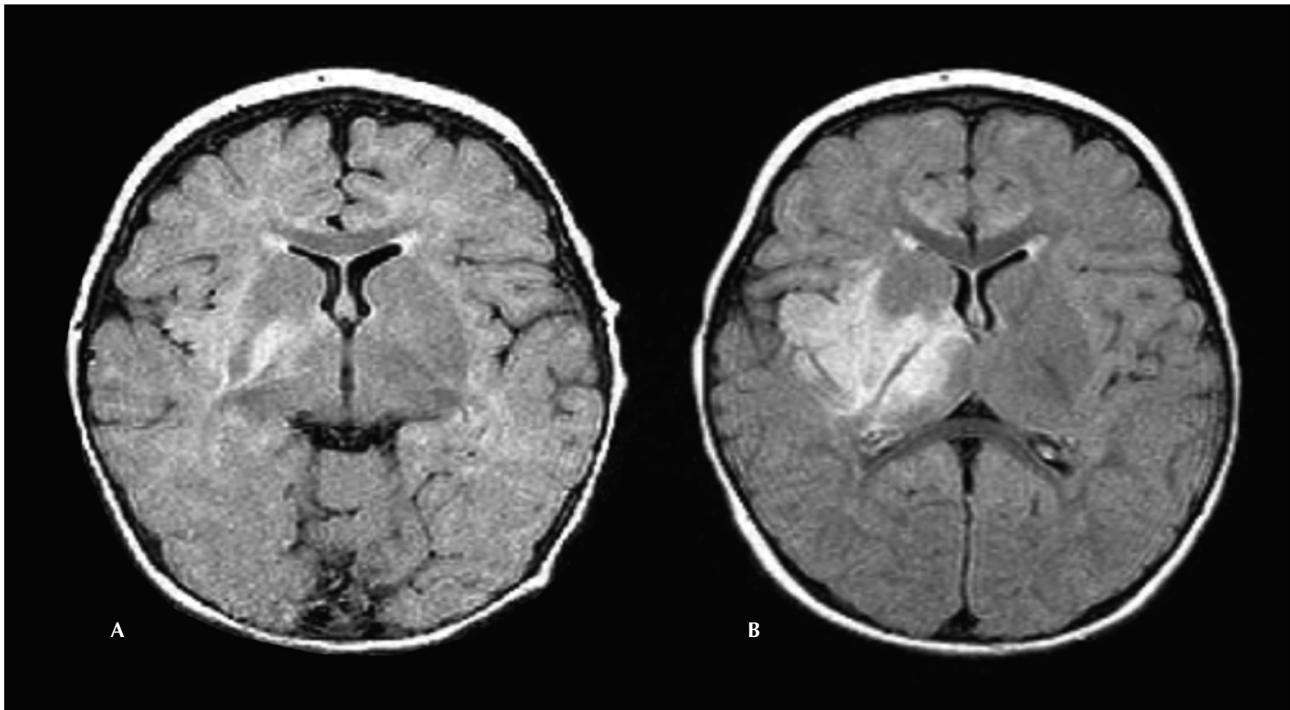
A) MRI brain; FLAIR images (TR 9002, TE 129.7, inversion time 2200) at 11 months showing the lesion involving the right globus pallidus and lentiform nucleus, which extended to the right external capsule and adjacent cortical region. B) Repeat MRI brain FLAIR images at 17 months shows the lesion to involve the right putamen, pallidum, thalamus, peri-Sylvian region extending into the adjacent posterior right frontal and mesial right temporal lobes with mild mass effect.
